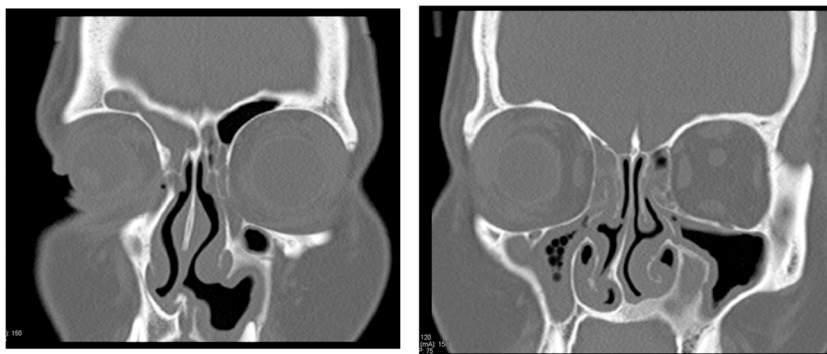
The coronal computed tomography images six months after the marsupialization.
